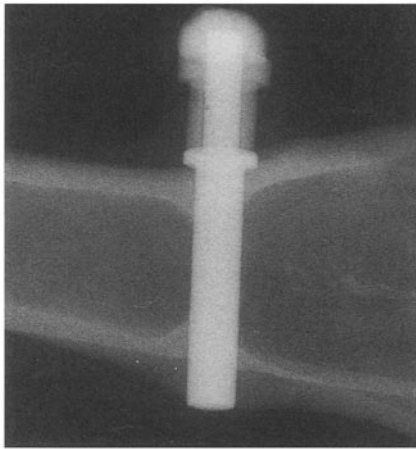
Radiograph of a tibia implant 9 months postoperatively.
